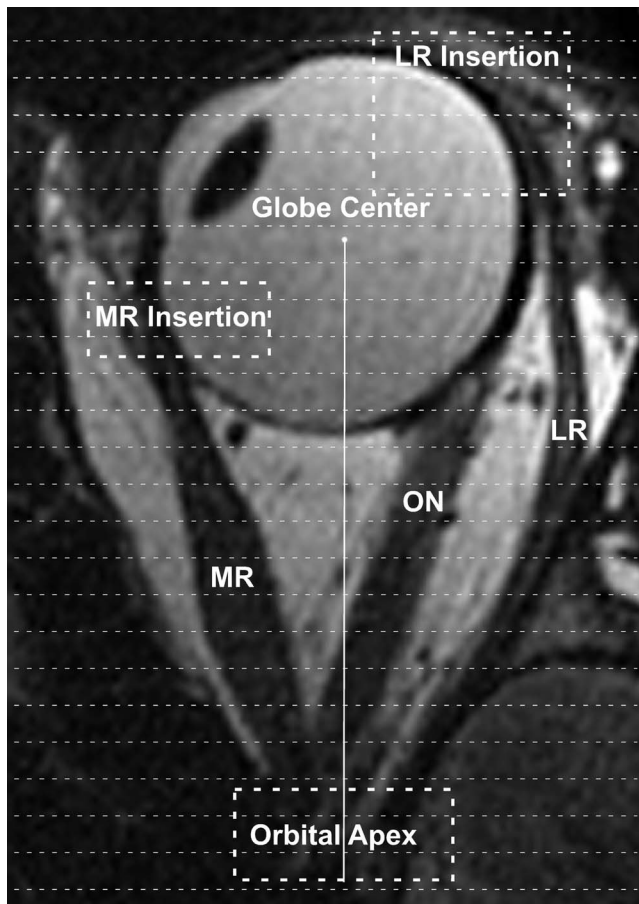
Axial magnetic resonance image of the left eye in adduction. The terminal cross-sectional areas of the MR and LR near the orbital apex and insertions onto the globe (*enclosed dashed rectangles*) could not be directly measured on coronal imaging. Volumes within these regions were estimated by dividing the segments of unresolvable cross sections into 2-mm slices (*thin dashed lines*). The number of slices required to span the terminal segments was multiplied by the terminal measured cross-sectional areas and then by the 2-mm slice thickness. ON, optic nerve.
